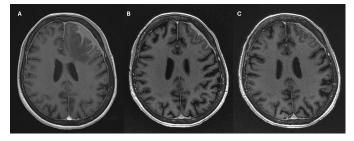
Contrast-enhanced thin-slice axial T1-weighted image at the time of BNS diagnosis is shown on the left (A). Follow-up images at 4 months (B) and 6 months (C) demonstrate marked regression of dural and leptomeningeal infiltration, with complete resolution of vasogenic edema.
